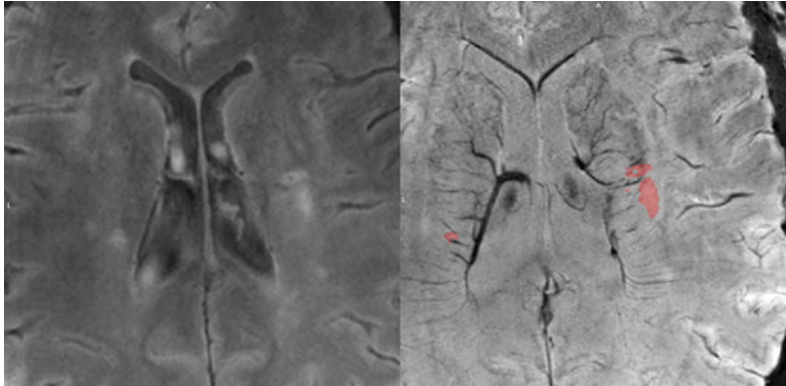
7 T FLAIR (left panel) and SWI (right panel) MRI of a patient with ischaemic stroke. FLAIR hyperintensities were superimposed onto SWI to show the interaction between features thought to represent SVD and the small vessels themselves. It is just one image slice
